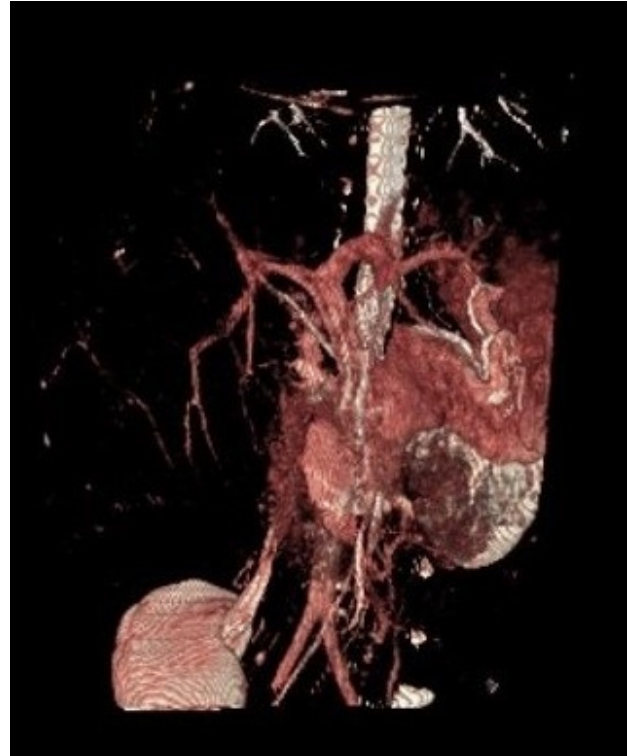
CT angiography, coronal plane, 3D reconstruction.
